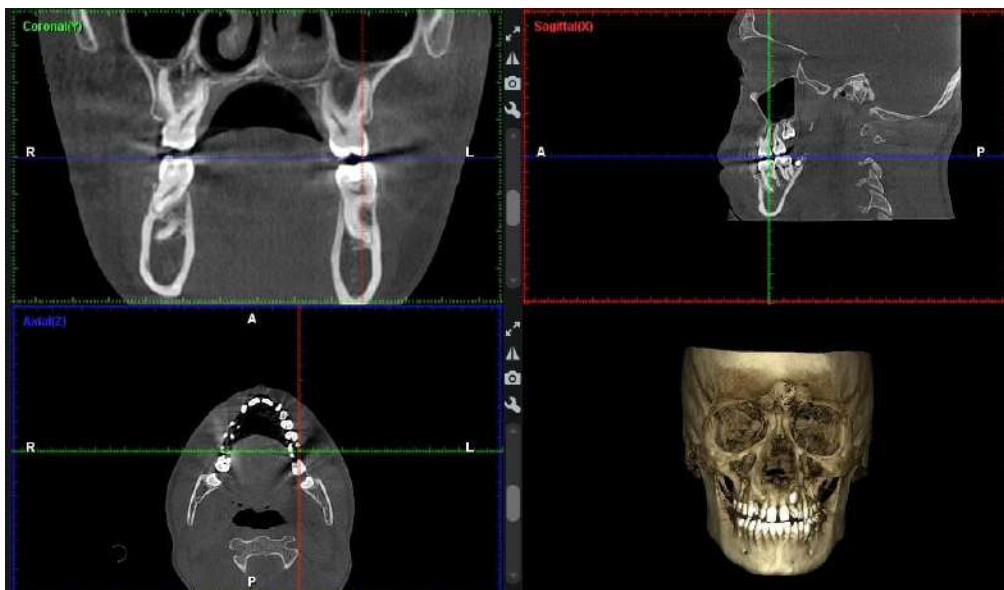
CBCT image being oriented in all three planes. Coronal, sagittal, axial view to locate accurately the distobuccal root of maxillary 1st molar
